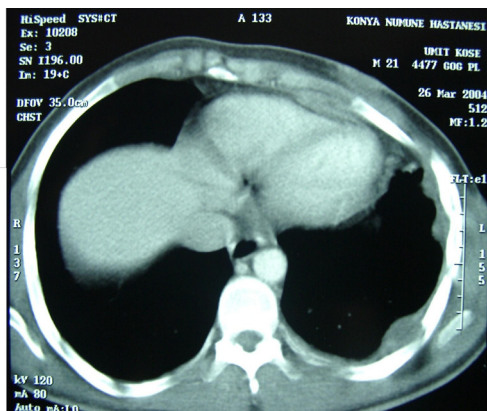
CT Scan in day of admission
